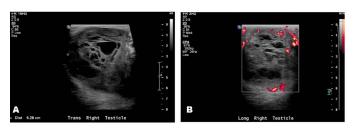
(A) Right testicular ultrasonography demonstrating heterogeneous, mixed cystic, and solid mass. (B) Right testicular ultrasonography with Doppler.
